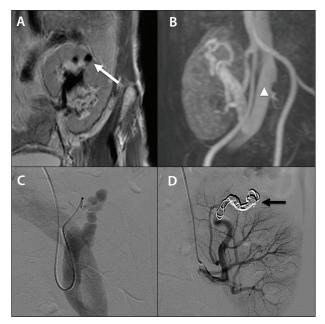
MRI showing a 1-cm AVF (arrow) (A). Large dilation of the renal vein (arrowhead) (B). The microcatheter was introduced into the AVF in order to preserve the renal branches (C). Embolization performed with one POD8 (arrow) (D).
